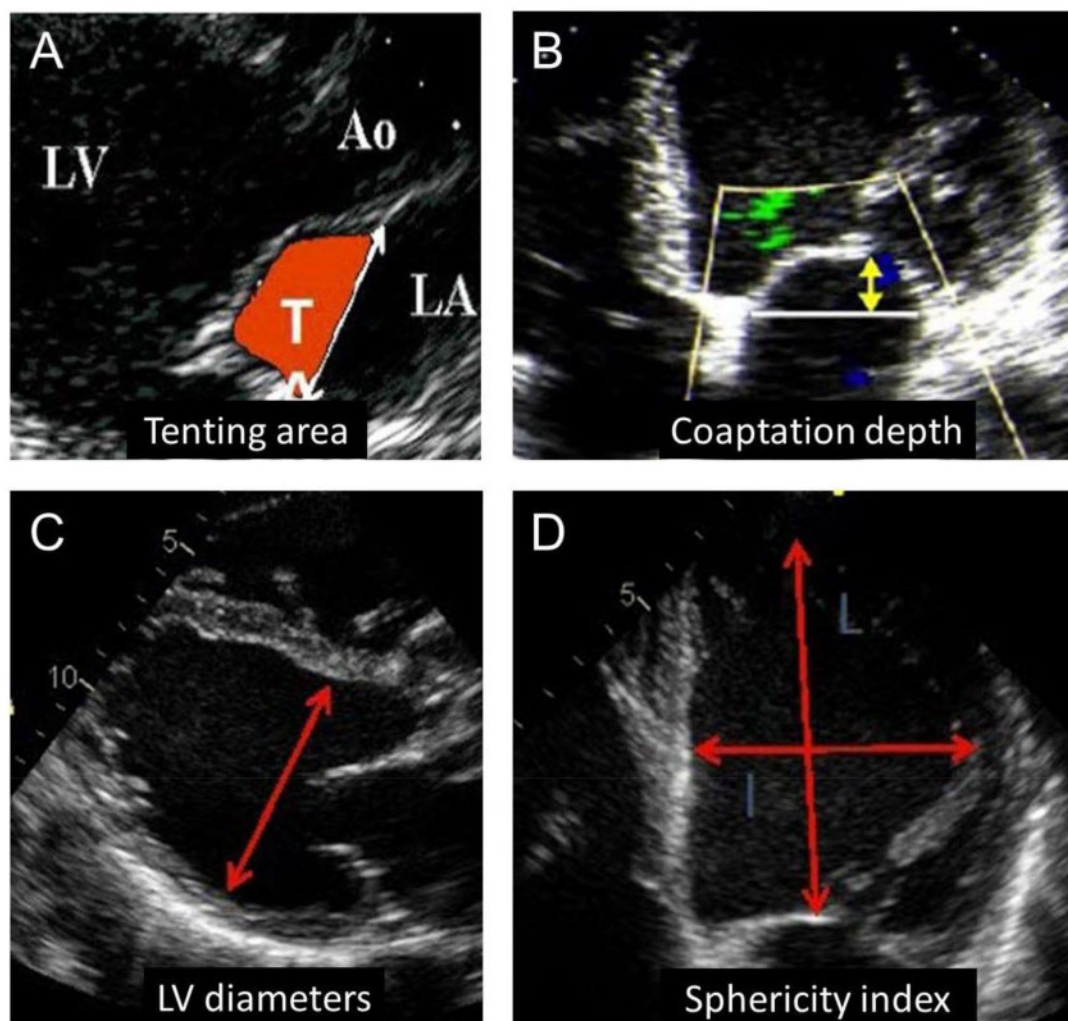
Key echocardiographic data in secondary mitral regurgitation concerning the mitral valve (A, B) and left ventricle (C, D). (A) The tenting area (highlighted in red) is bound by the anterior and posterior leaflets and the mitral annular plane (white arrow). (B) Coaptation depth represents the distance from the annular plane of the mitral valve to the leaflet coaptation point (yellow arrow). (C) The LV diameter (red arrow) must be measured in end-diastole and end-systole. (D) Sphericity index is the ratio between the measured end-diastolic volume (EDV) and a spherical volume based on the longitudinal dimension of the left ventricle. Ao, aorta; LA, left atrium; LV, left ventricle; T, tenting area.
